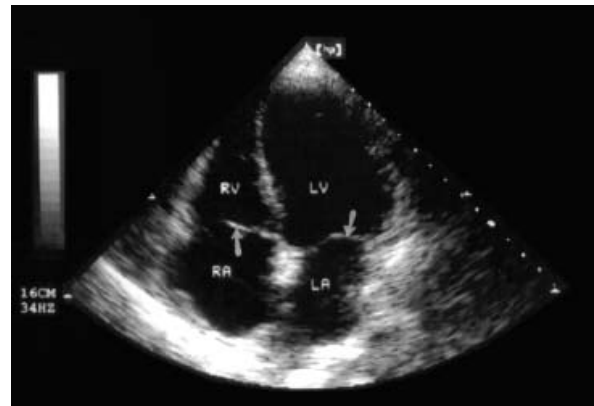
An apical "4-chamber" view from a normal adult by two-dimensional echocardiography. Leaflets of the tricuspid and mitral valves (arrows) are seen between the right atrium and ventricle (RA and RV) and between the left atrium and ventricle (LA and LV), respectively. (Figure courtesy of L.Targa, MD, Division of Cardiology, Este Hospital, Padova, Italy.)
